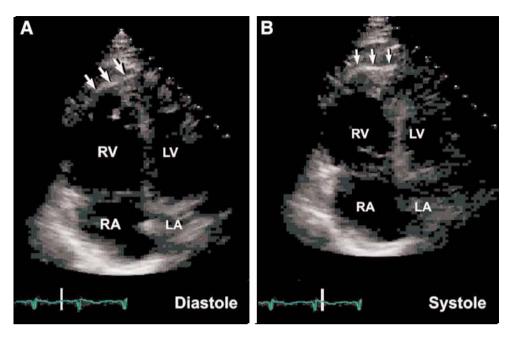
Apical four-chamber view from patient in Figs. 3 and 4 demonstrates an enlarged and severely hypokinetic right ventricle (RV) with moderate tricuspid regurgitation (arrow). (Please *see* companion DVD for corresponding video.)
